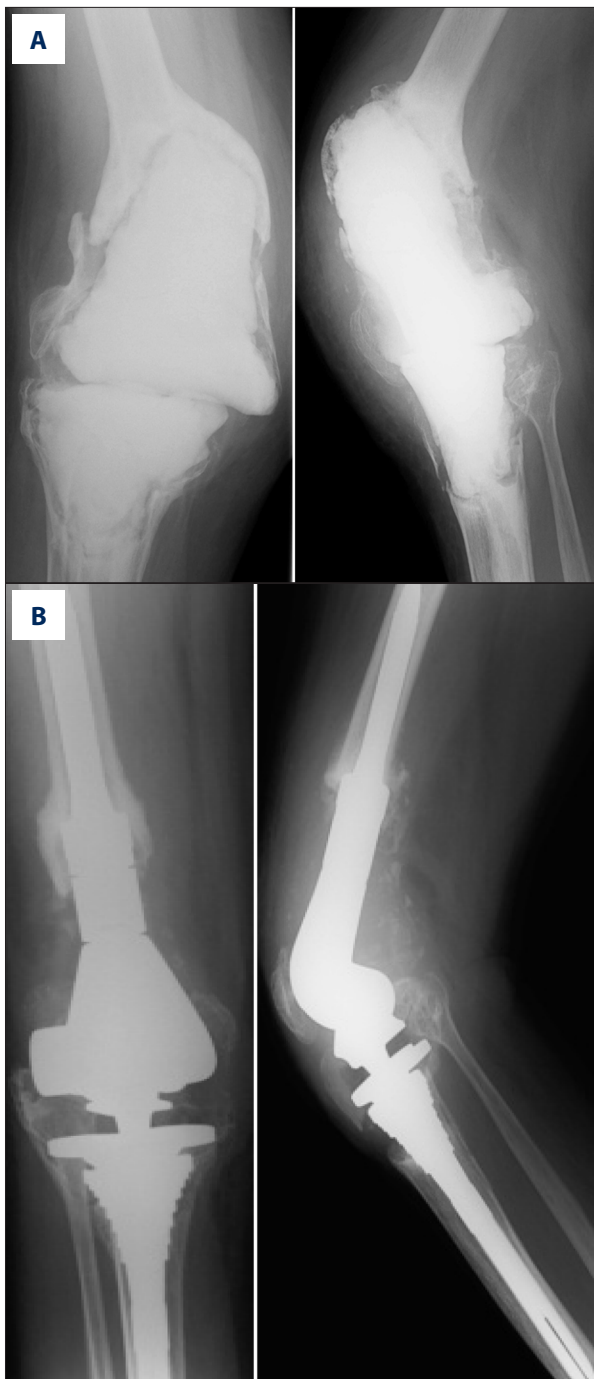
Case 3: (A) antibiotic-loaded knee spacer (pre-operative view), (B) post-operative radiograph 2 years after the operation, and (C) implant migration (arrows).
